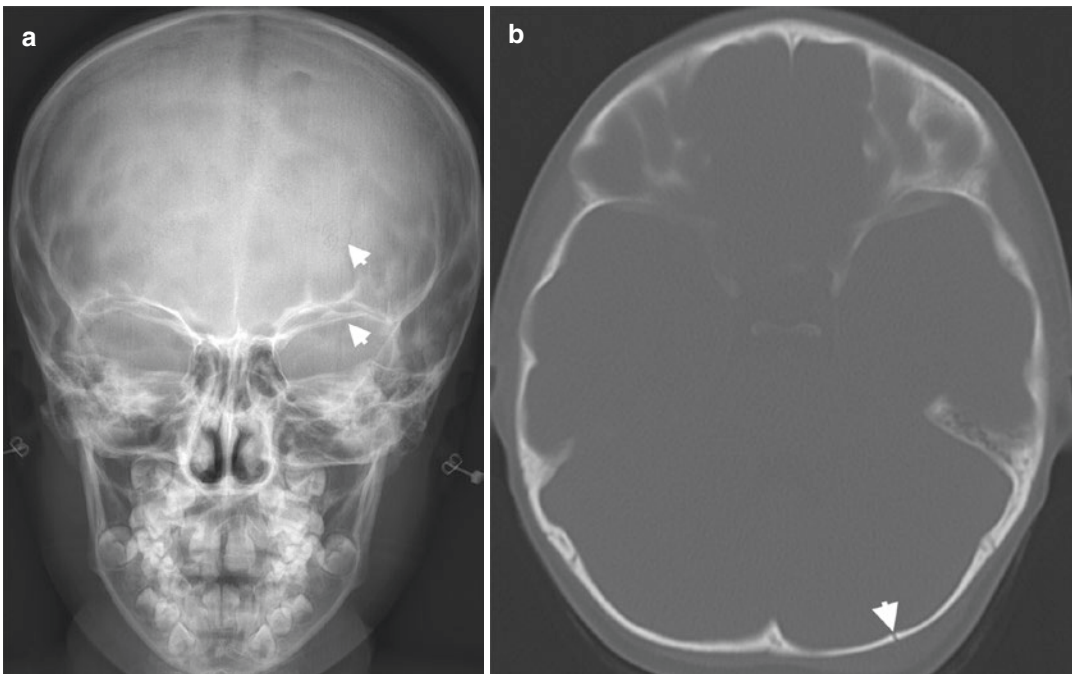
Linear fracture in occipital bone. (a) A-P view of skull radiograph of a 6-year-old female patient presented to emergency department after fall reveals a unilateral linear vertically extending radiolucency (arrowheads) in left
